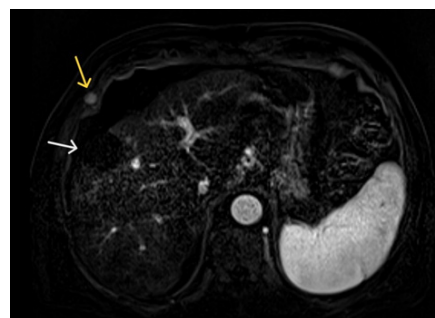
T1-weighted image post-contrast with subtraction with stable post-ablation changes (white arrow). A small thoracic wall nodule was overlooked (yellow arrow).
